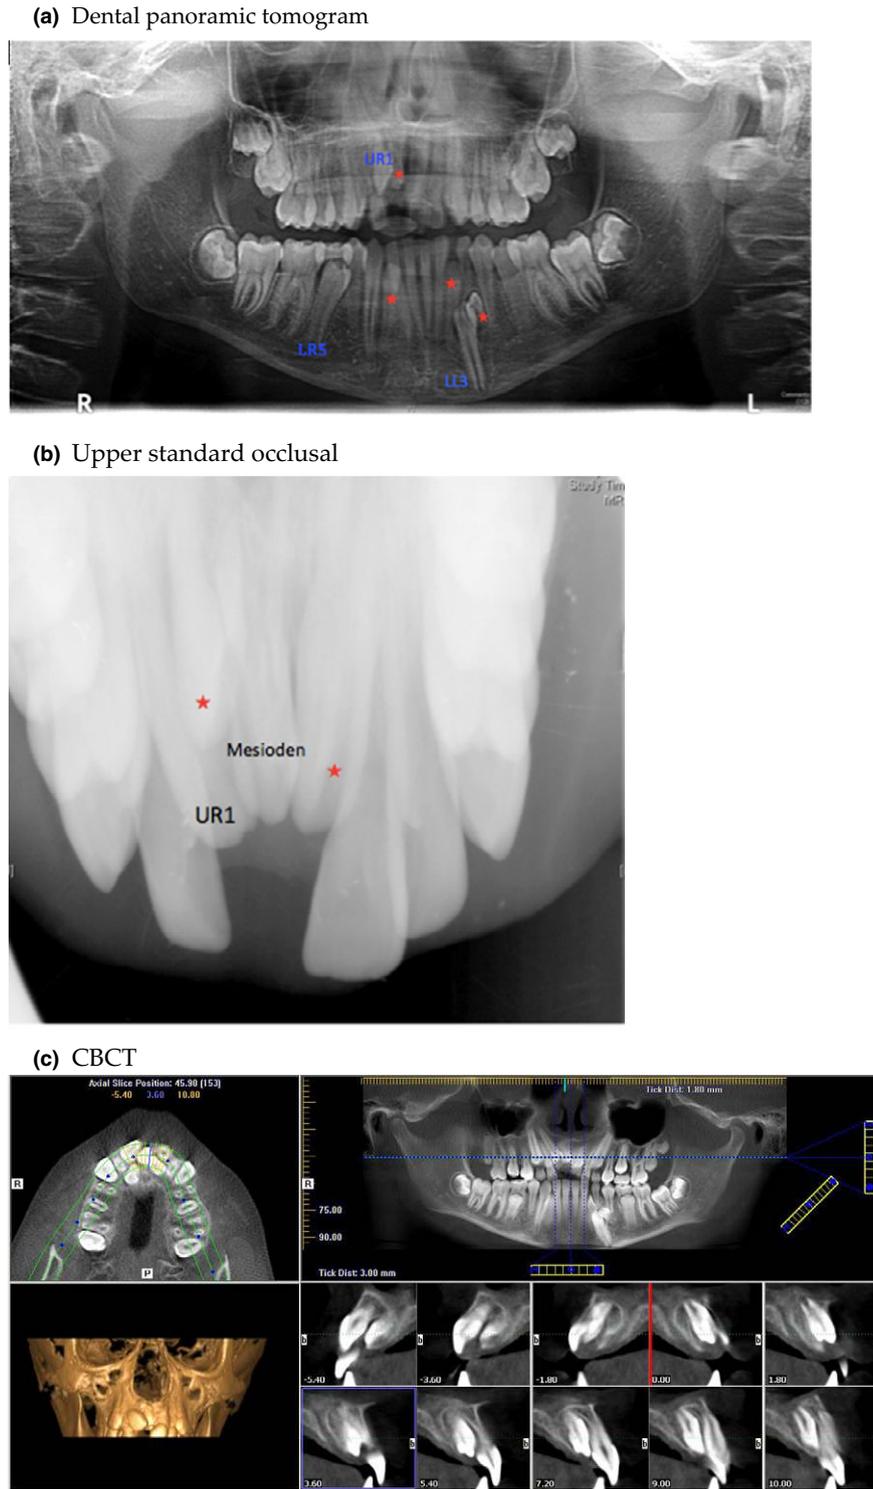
Radiographic findings. The dental panoramic tomogram (DPT) (a) clearly reveals the presence of three supernumeraries (★) in the mandible and an impacted UR1, LL3, and LR5. The two supernumeraries palatal to the central incisors and the mesiodens are not clearly visible on the DPT due to the focal trough however, are visible on the upper standard occlusal (b). Cone beam computed tomography (c) confirming the presence and position of all six supernumeraries.
